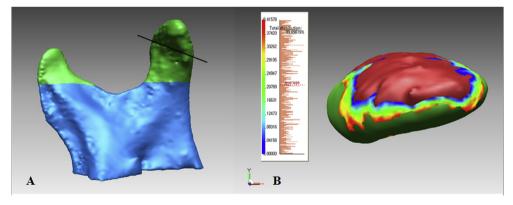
(A) cone beam computed tomographic three-dimensional condylar image. Blue shows superimposed registration areas, and the upper part of the line shows condylar head surface analysis areas. (B) Superimposed upper condylar head. These are the absolute linear measurements. Green indicates T0, and red T1.
